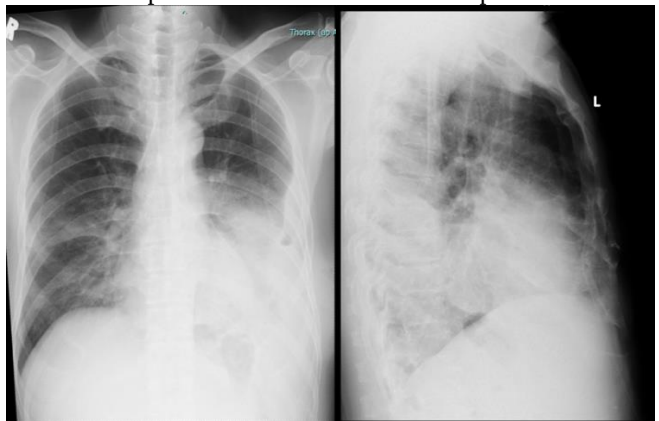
X-ray AP view (left) and lateral view (right) 3 days after chest tube removal
